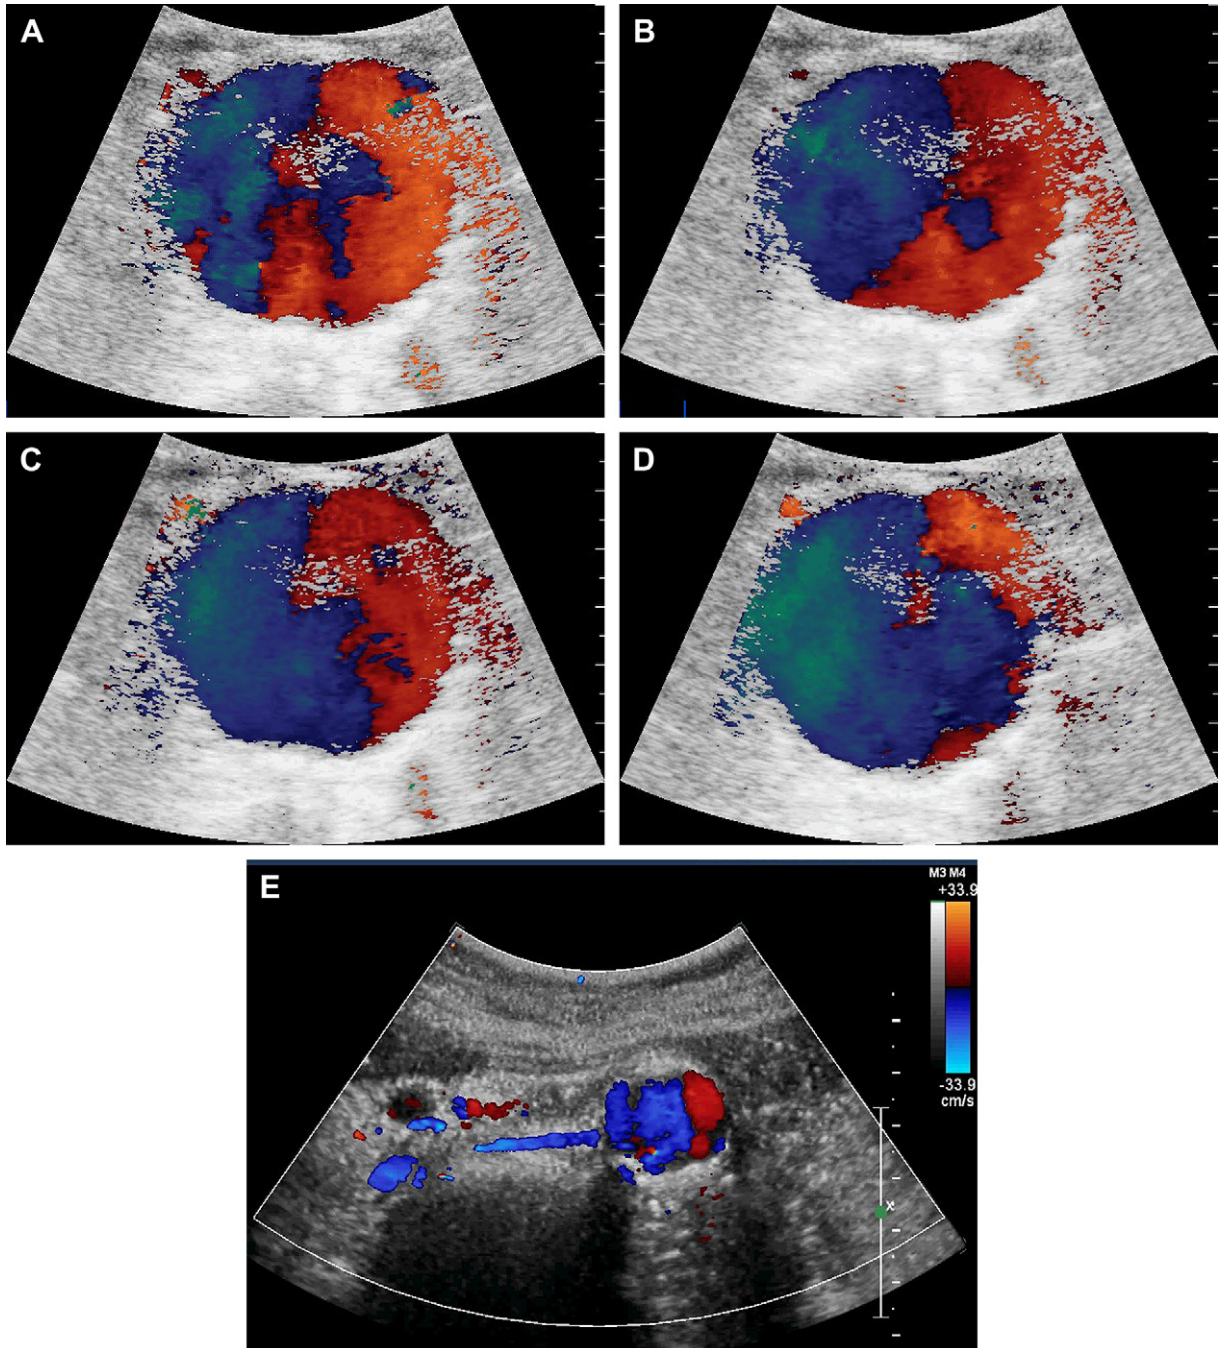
On Color Doppler, the aneurysm is characterized by swirling flow with decreased linear velocity. The figures show the Color Doppler flow of an abdominal aortic aneurysm (A, B, C, D, E).
